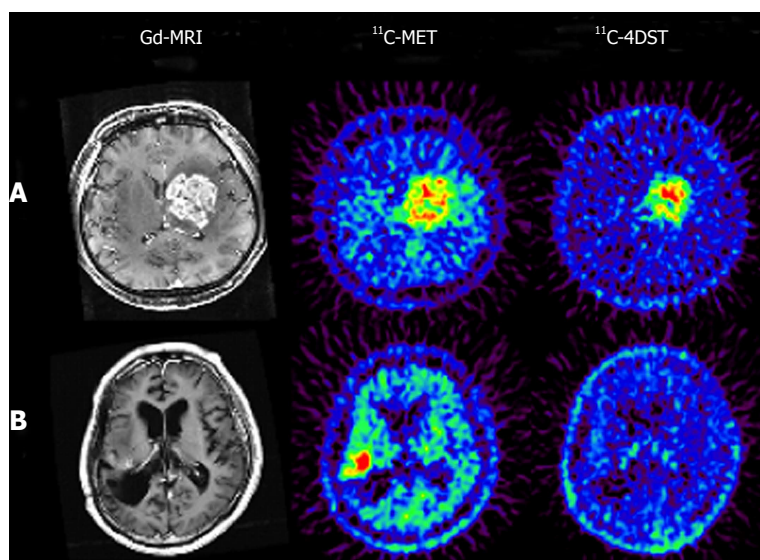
Brain tumor imaging in temozolomide-resistant (A) and -responsive (B) patients. DNA synthesis images provide completely different information from those obtained with an amino acid transport agent. In the case of recurrent anaplastic oligodendroglioma (A), both ^{11}C -MET and ^{11}C -4DST showed high uptake in the gadolinium-enhanced region of the MRI. However, the distribution pattern of each tracer in the tumor region was not identical. The tumor in this patient showed progressive enlargement despite continuous treatment with the DNA alkylating agent temozolomide. In the case of recurrent anaplastic astrocytoma (B), the patient received one course of treatment with temozolomide 3 d before PET examinations, and it was found that the ^{11}C -4DST uptake was negligible in the gadolinium-enhanced region where high uptake of ^{11}C -MET was observed. The enhanced tumor mass in this patient remained unchanged over 6 mo after commencement of temozolomide treatment. These observations suggest that DNA synthesis in the tumor was suspended by temozolomide treatment. Reprinted from Nariai *et al*^[14], with the permission of Springer. ^{11}C -4DST: 4'-[methyl- ^{11}C]-thiothymidine; ^{11}C -MET: ^{11}C -Methionine; Gd-MRI: Gadolinium-enhanced magnetic resonance image; PET: Positron emission tomography.
